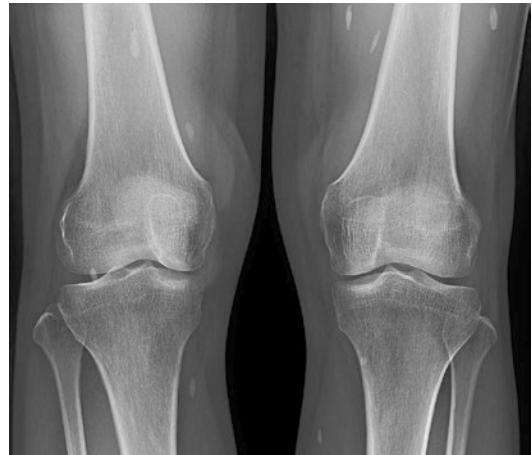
Frontal plain film radiograph of the bilateral knees of a 57-year-old female demonstrates calcifications in the soft tissues and muscles. The calcified cysticerci are aligned with their long axes in the plane of the muscle bundles of the legs
